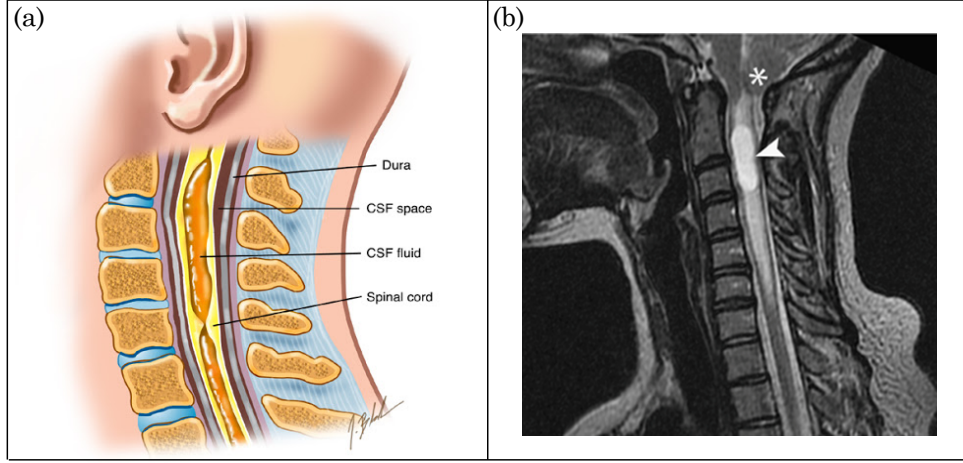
Syringomyelia. (a) Graphical representation of the disease (image taken from [124]) (b) MRI image of a syrinx (indicated by the arrow) associated with Chiari I malformation (indicated by the star) (image taken from [32])
